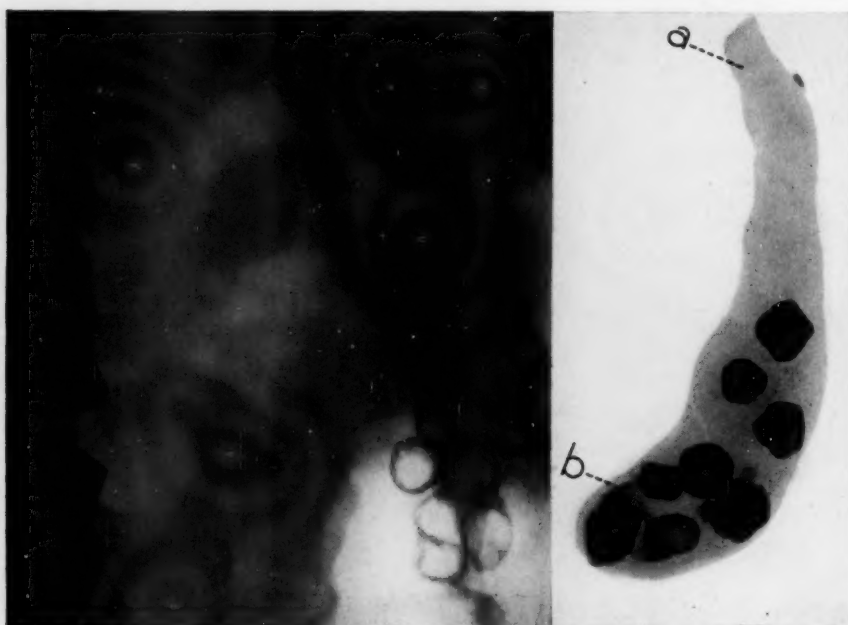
Case 3: Roentgenogram before dye administration showing eight ring shadows of calcium density. Gallbladder did not visualize with dye.
